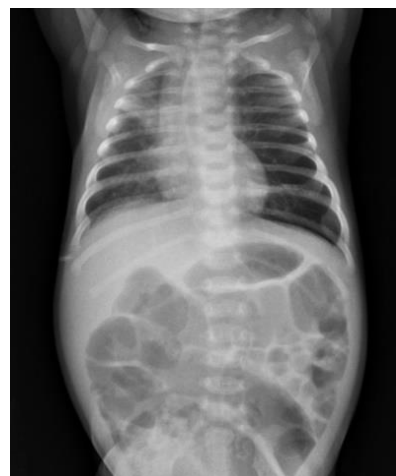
The x-ray showing Congenital lobar emphysema LUL
